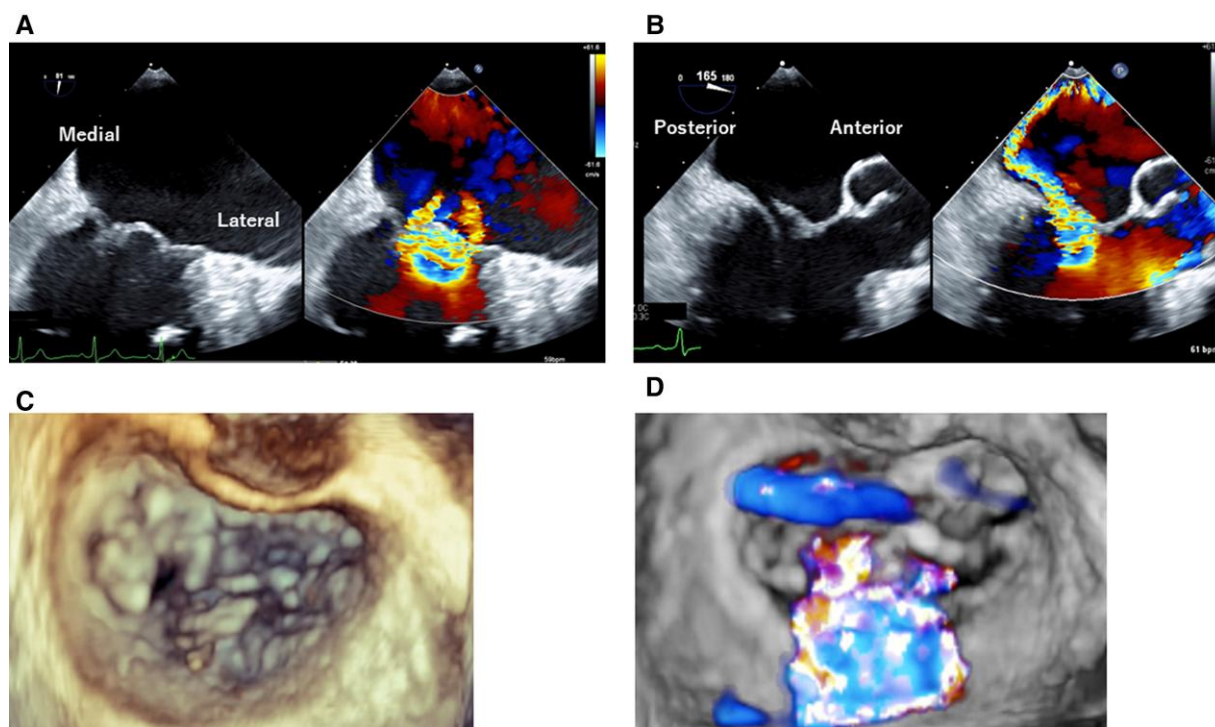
Transoesophageal echocardiography images at baseline before the first clipping. (A) Mitral regurgitation from the centre of the mitral valve in the inter-commissural view. (B) Severe mitral regurgitation is confirmed due to A2 (middle segment of the anterior leaflet) prolapse on the apical long-axis view. (C) Three-dimensional image of the mitral valve. (D) Three-dimensional colour image of the mitral valve.
